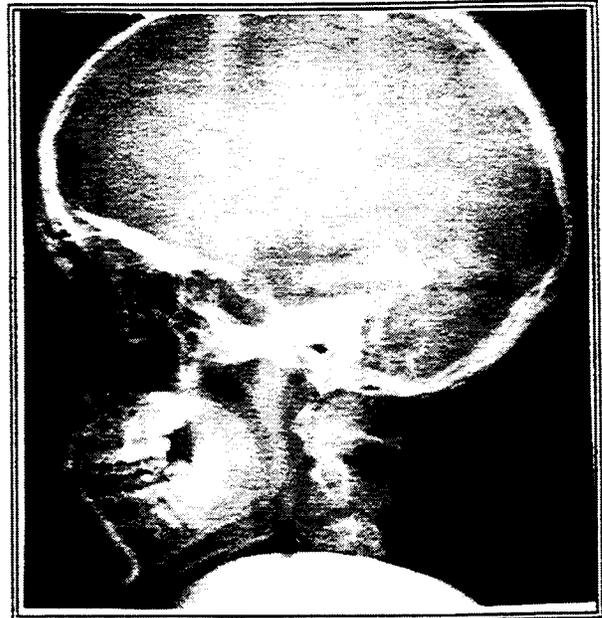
Lateral X-ray of the Skull
